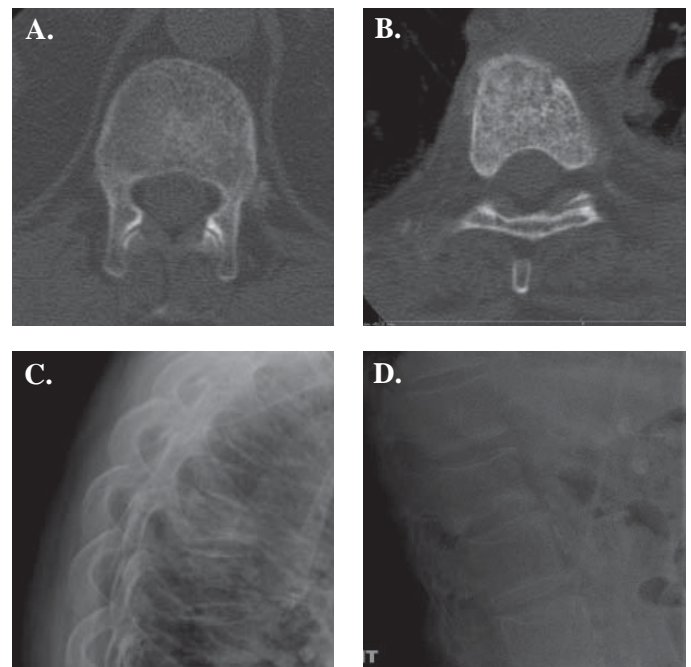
Pre-operative evaluations included imaging studies to assess the baseline condition. Axial CT and lateral x-rays identify the fractured levels in patients randomized with Cortoss (A & C) and PMMA (B & D).
